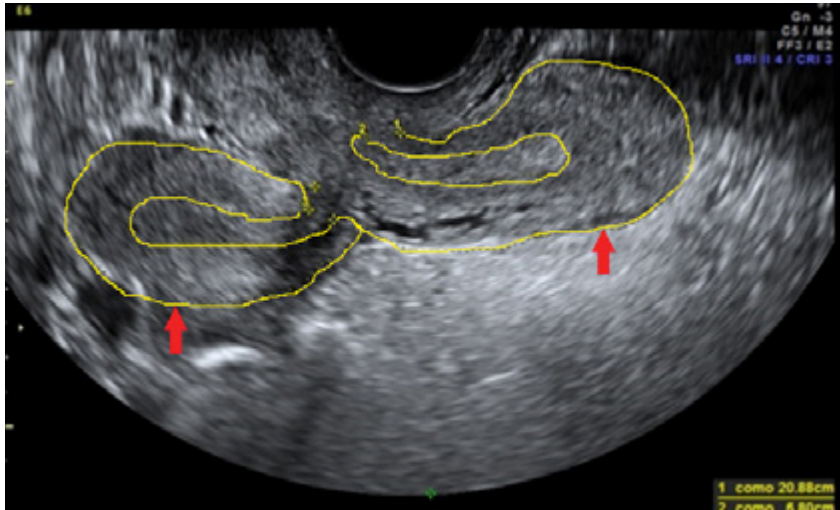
Transvaginal gynecology ultrasound showing the presence of uterus didelphys (demarcated in yellow).
